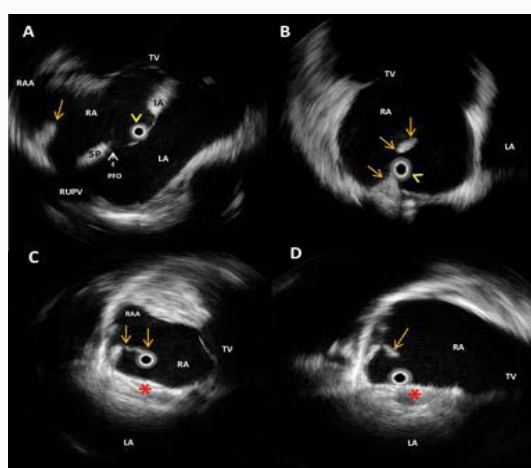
Rotational Intracardiac Echo by Ultra-ICE (mechanical 9F/9 MHz 360° scan probe). Pre-procedural long-axis four-chamber (A) and axial plane (B) showing the interatrial septum with its inferior–anterior and superior–posterior rims and the Patent Foramen Ovale. The prominent Crista Terminalis (CT) (orange arrow) appears as a prominent thick structure, at the junction between the posterior smooth wall and the anterolateral trabeculated portion of the right atrium, keeping contact in the axial plane with the Ultra ICE catheter (yellow arrowhead) located at the center of the images. Post-procedural axial planes (C, D) showing the correctly positioned Figulla Flex II PFO device (red asterisk) and CT (orange arrows) keeping contact mostly during systole with the Ultra ICE catheter without impingement/interference with the device.
